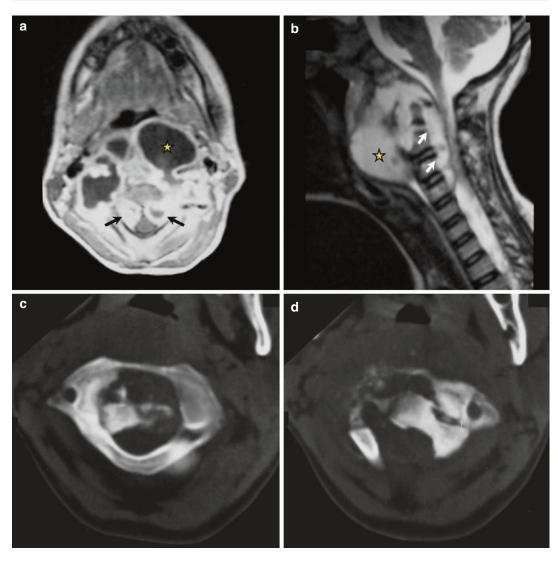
Craniocervical dysjunction, retropharyngeal abscess (*star*) and spinal cord compression (*arrows*) due to suboccipital TB. Axial MRI on T1-weighted image
